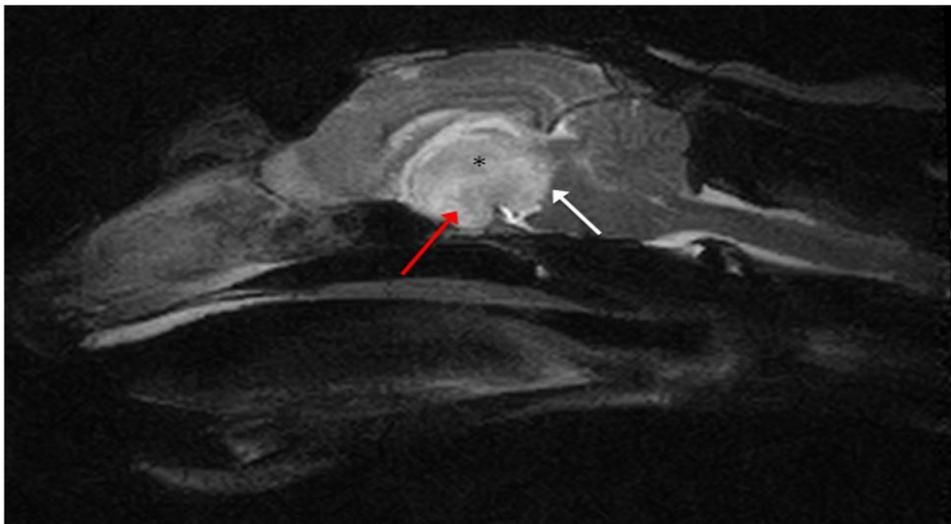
Mid-sagittal T2-weighted image of the brain. A hyperintense round mass (*) that extends ventrally in the pituitary (red arrow) area and caudally compressing the brain stem (white arrow) is visible in the thalamic region.
